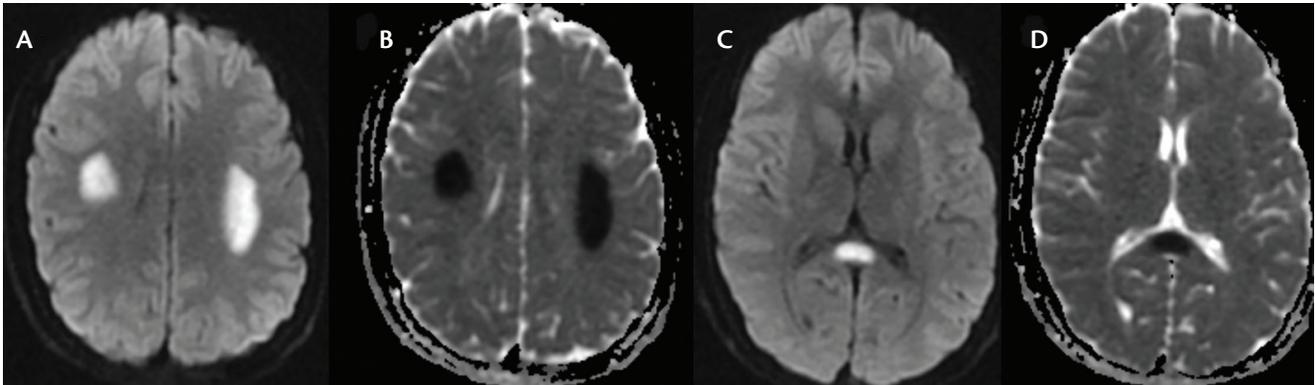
Brain MRI at 14 years of age. Diffusion-weighted image sequence (A, C) and apparent diffusion coefficient (B, D) showing restricted diffusion in the centrum semiovale (A, B) and the splenium of the corpus callosum (C, D).
